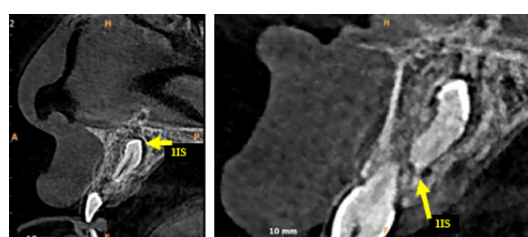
CBCT images revealed the presence of multiple supernumerary teeth in the anterior maxillary region
